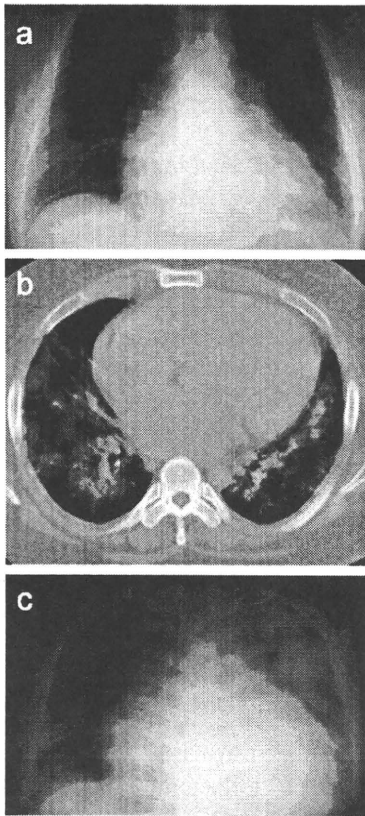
Radiograph of the lung and chest computed tomography (CT). (a) The radiograph showed nodular infiltrates in lower lungs on day 6. (b) The chest CT scan revealed severe bilateral consolidations on day 6. (c) The radiograph showed progressive and confluent consolidations on day 8.
